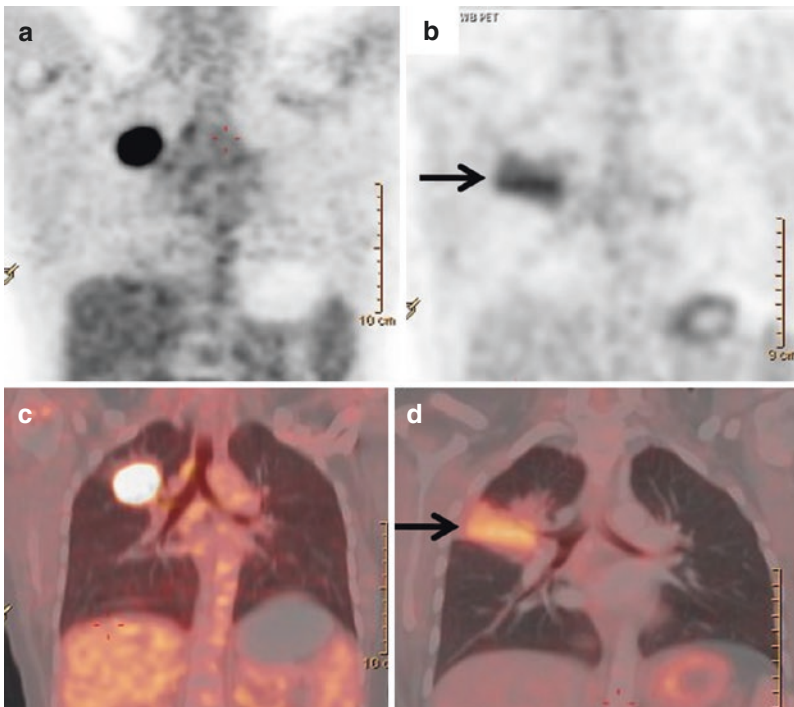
Whole-body FDG PET/CT scan of a 50-year-old gentleman with adenocarcinoma of the right lung (a, c). PET/CT scan was done 3 months post-external beam radiotherapy. The coronal PET and PET/CT images (b, d) show FDG-avid consolidation in the radiation port of the involved lung. The consolidation typically has a linear configuration typical of radiation-induced pneumonitis
